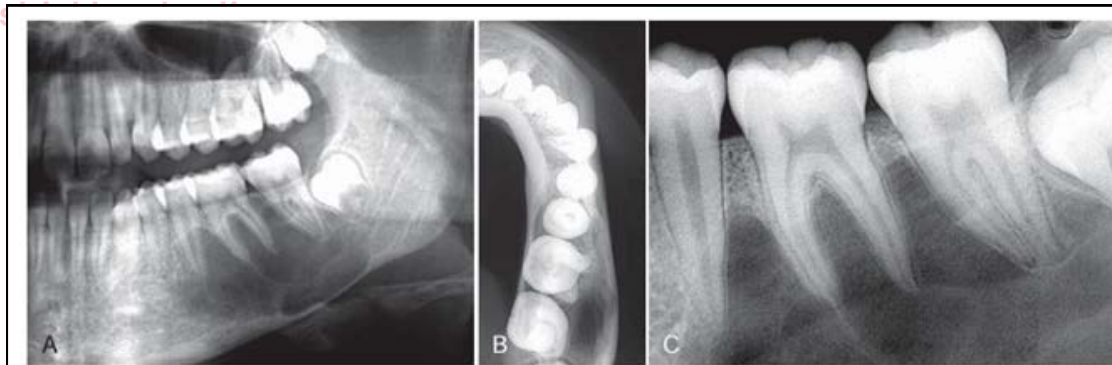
A panoramic film demonstrating an SBC (A), an occlusal film (B), and a periapical film (C). The occlusal film shows that no expansion has occurred in the buccal or lingual cortical plates. Except for the superior border, the borders are ill defined and the lesion has scalloped around the teeth and thinned the inferior border of the mandible, but the lamina dura is still present.
